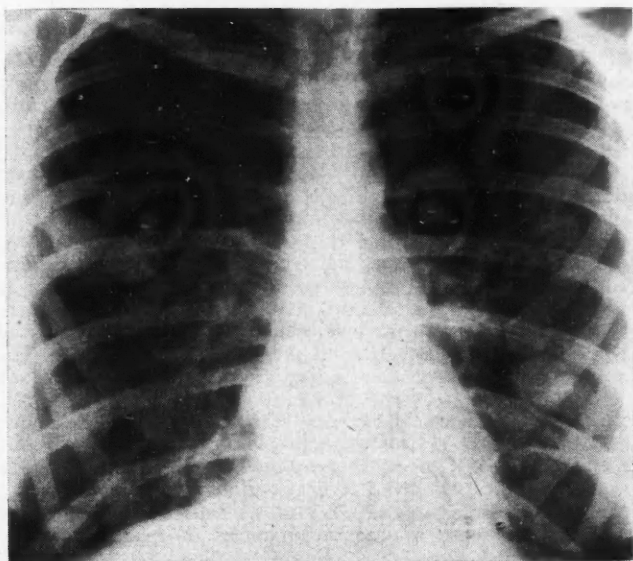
Chest roentgenogram taken May 21, 1953.
